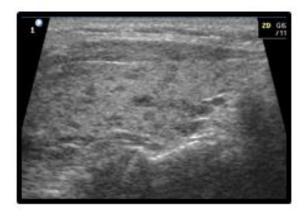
A: US B: Colour Doppler showing multiple , variable sized hypo and isoechoic nodules (MNG)
